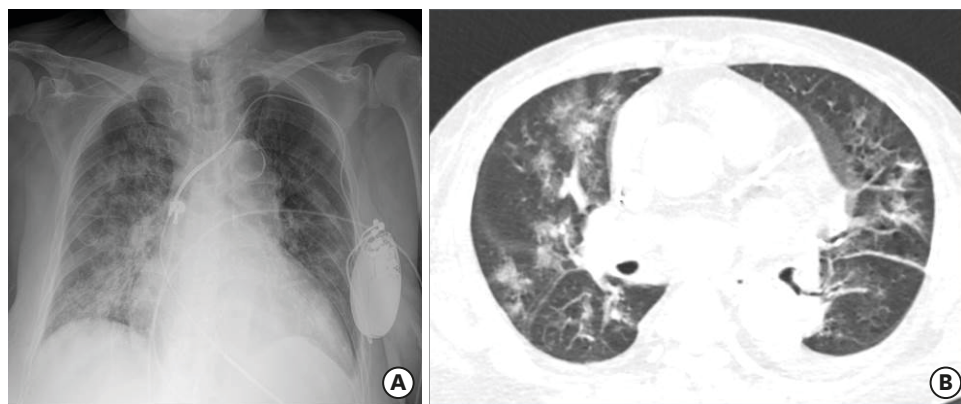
Chest X-ray (A) and chest CT (B) interpreted as pulmonary edema.
